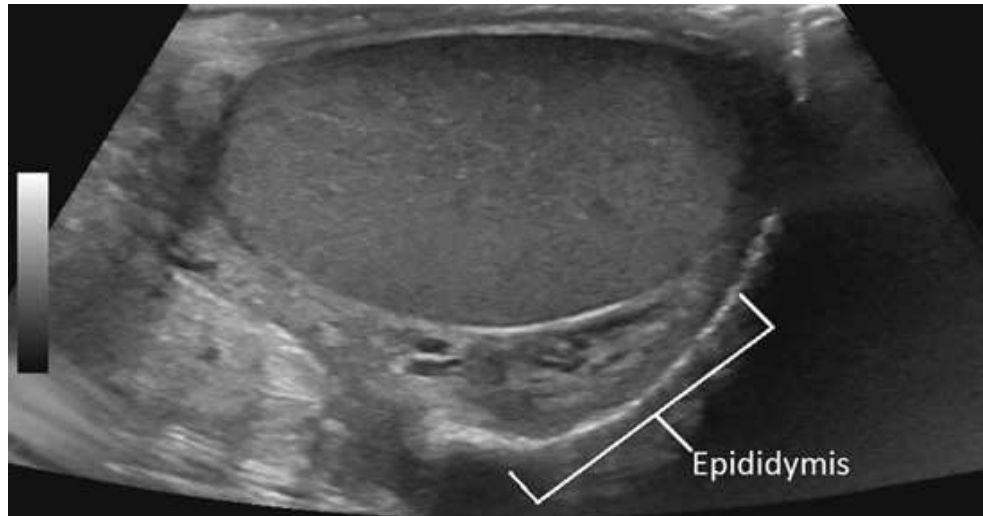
Ultrasound image of normal left testicle and epididymis, sagittal plane. Courtesy Nisa Hinklin, RT[R], RDMS[AB], NEA Baptist Memorial Hospital, Jonesboro, AR.
